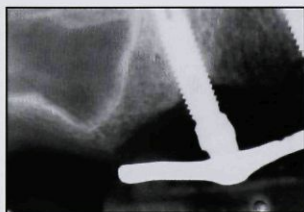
(left) Periapical radiograph of the maxillary area from patient LT, just before sinus elevation.
